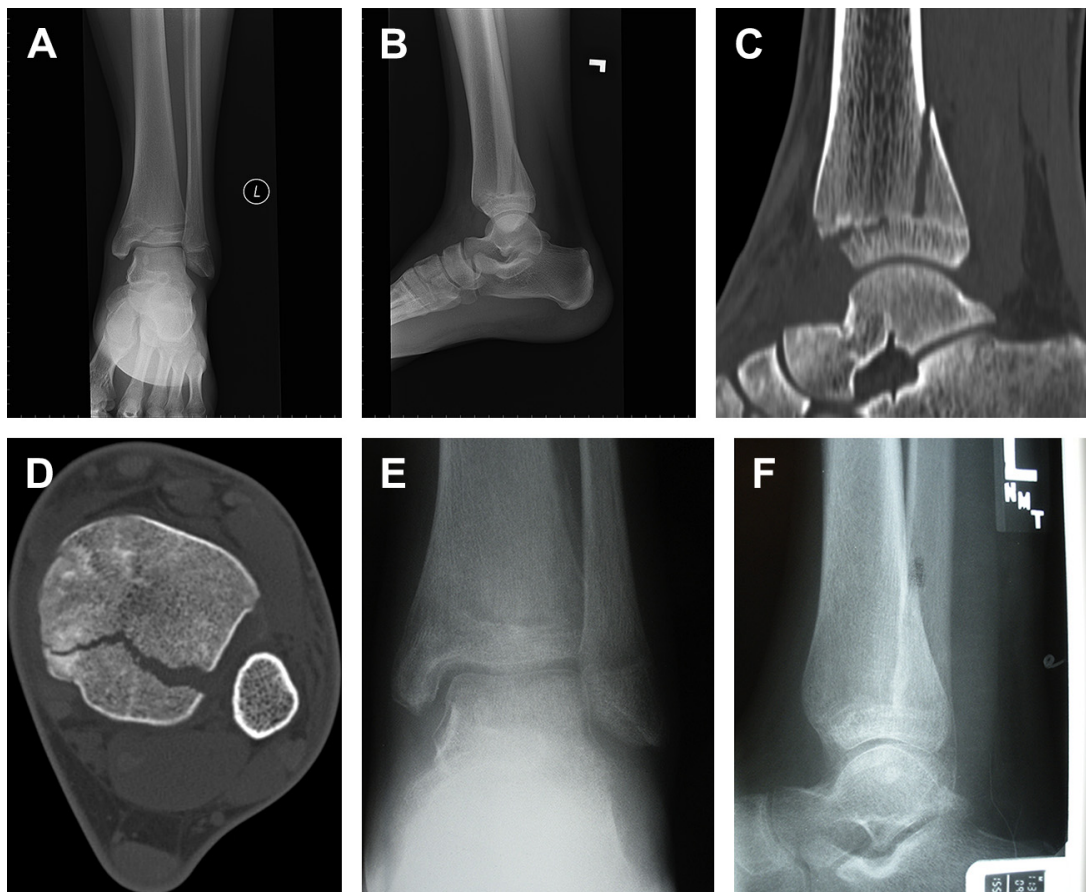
(A) AP radiograph of triplane fracture. The type 3 fracture is easily visible. The type 2 metaphyseal fracture is present but is subtle on this view. (B) Lateral view showing typical physeal displacement and typical metaphyseal fracture orientation. (C) CT view showing sagittal displacement of the tibia. (D) Minimal displacement of the epiphysis fracture is noted on CT scan. (E, F) Closed reduction under general anesthesia was accomplished, and a long leg cast was placed to maintain reduction. Because minimal epiphysis displacement was present, closed reduction resulted in good position and healing.
